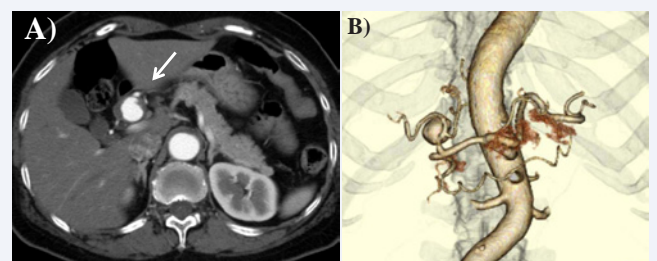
Computed tomography (CT) findings. A) Enhanced abdominal CT examination shows a saccular aneurysm of the proper hepatic artery (PHA), 2.9 cm in diameter (arrow). B) 3-dimensional CT angiography shows the aneurysm arising from the distal site of the PHA. The aneurysm is shown having a narrow neck.
